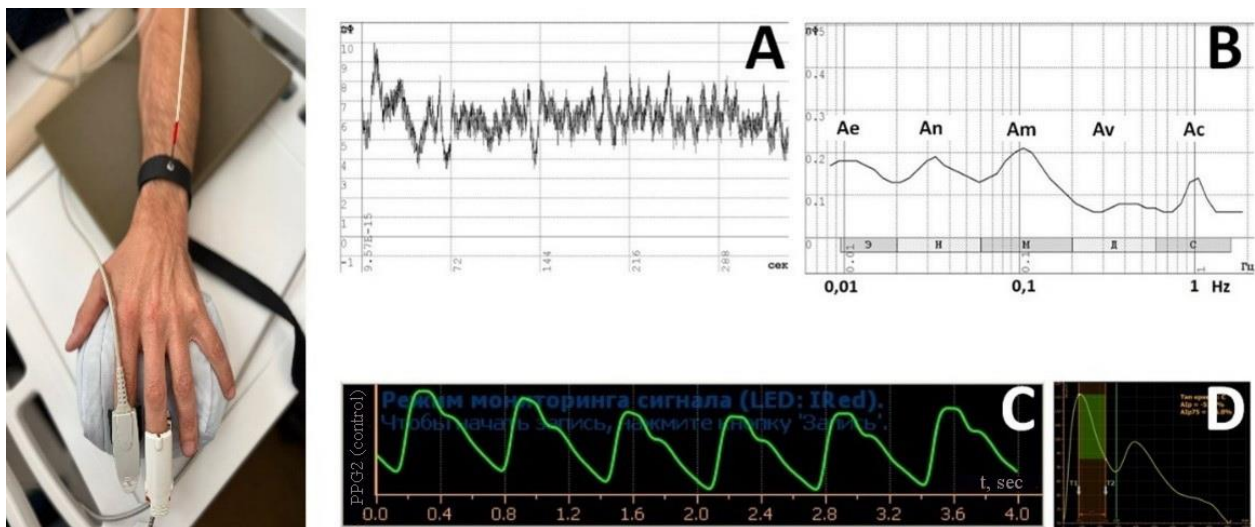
Laser Doppler flowmetry (LDF) on the middle finger and forearm and photoplethysmography (PPG) on the index finger. A, LDF-gram of basal perfusion. B, amplitude-frequency wavelet analysis of skin perfusion fluctuations in basal perfusion (logarithmic scale). C, photoplethysmography recording. D, pulse wave contour analysis.
